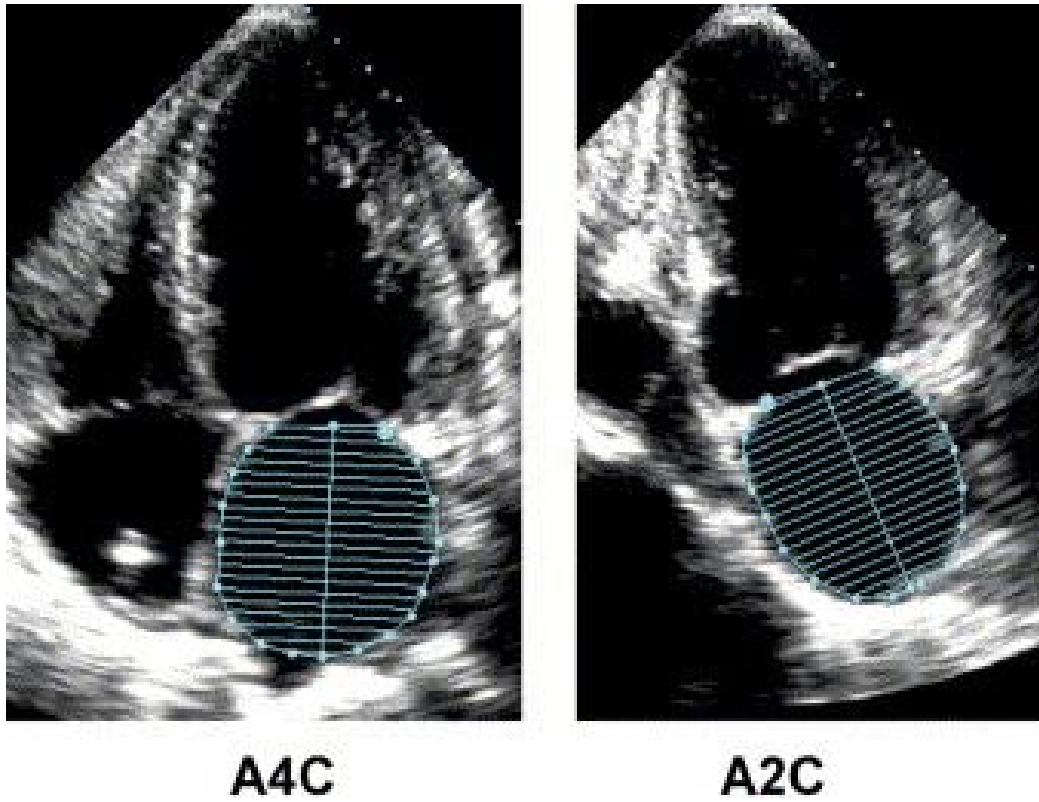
Apical four (A4C) and two chamber (A2C) views for LA area measurements which are in turn used to calculate LA volume.
